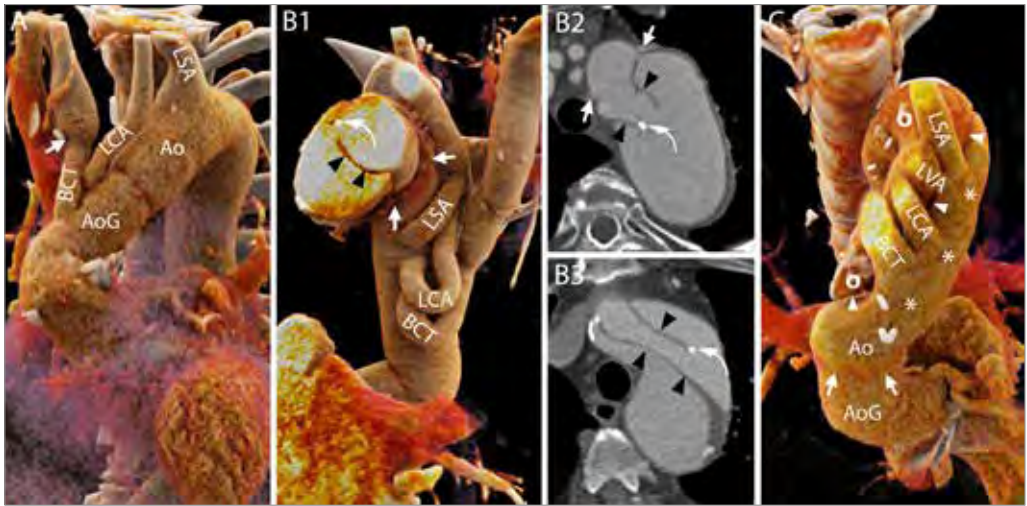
Normal aspect of the aortic arch and aortic branches. A – Hemi-arch replacement. In this patient, the aorta was replaced up to the mid-arch. Therefore, only the brachiocephalic trunk (BCT) and the left carotid artery (LCA) were “debranched” and re-attached to the aortic graft with the interposition of surgical grafts. In some cases, the level of the suture line along the aortic branches can be easily recognized due to the mismatch of caliber between the native vessel and the graft (arrow). On the contrary, the left subclavian artery (LSA) was left attached to the native aortic arch. 3D reconstruction. B1-B2 and B3 – Elephant trunk (B1-B2) and confounders (B3). In case the entire arch has to be replaced and the descending aorta is dilated to such an extent that further interventions are required, the “Elephant trunk” technique can be employed. During the first step of this procedure, the aortic arch is replaced and sutured to the native aorta, where the felt used to reinforce the suture can be seen on CT images (B1 and B2, arrows), and the BCT, LCA and LSA are re-attached to the graft (B1). The most characteristic feature of the procedure is that the aortic graft has some additional fabric attached to the distal edge that is left floating freely in the lumen of the native aorta (thus the name “elephant trunk”) and will guide and ease future interventions on the proximal descending aorta. The fabric appears on CT images as hypodense lines (B1-B2, arrowheads) that should not be mistaken for intimal flaps that might have an analogous aspect (B3, arrowheads). Although a metallic component is added to the distal end of the trunk to ease its visualization (B1 and B2, curved arrows), intimal flaps can have similar looking calcifications (B3, curved arrows). B1 - 3D reconstruction. B2 and B3 - axial images. C – Residual dissection. Distal to the suture line (arrows) of the aortic graft the dissection can be left into place with its true lumen (asterisks) in continuity with the lumen of the graft. The aortic branches (including the independent origin of the left vertebral artery, LVA) all originated from the true lumen very close to the intimal flap (arrowheads) and the false lumen (circles). 3D reconstruction seen from above. Ao – native aorta, AoG – aortic graft, BCT – brachiocephalic trunk, LCA – left carotid artery, LSA – left subclavian artery, LVA – left vertebral artery.
